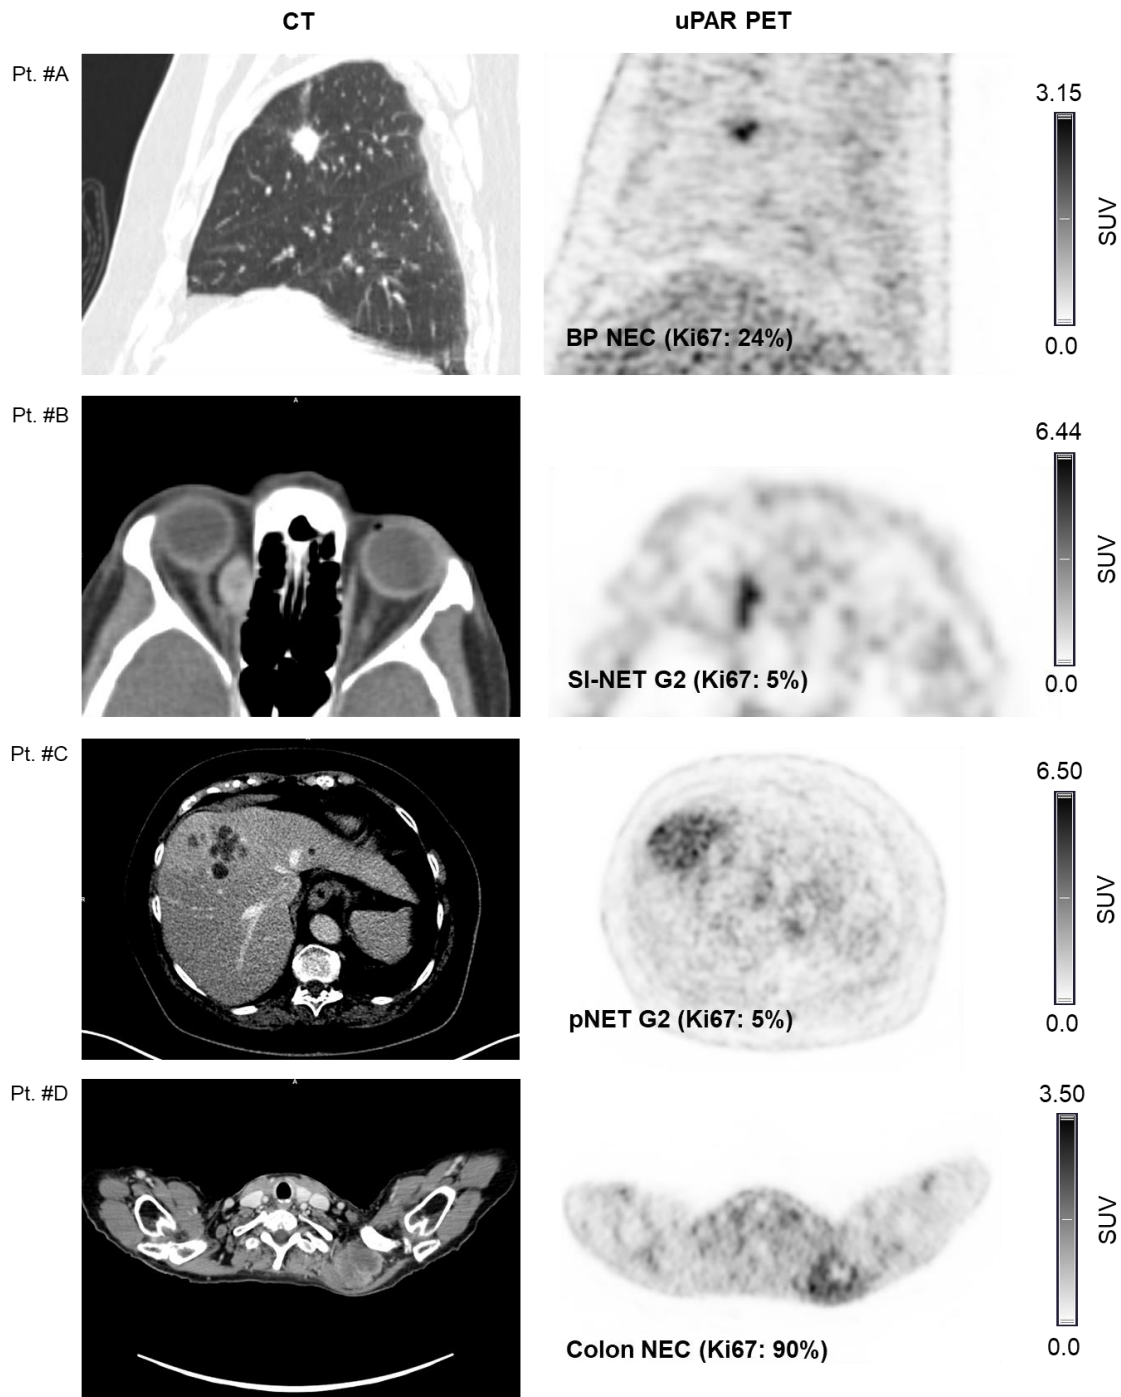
Representative examples of uPAR PET/CT imaging. CT (left column) and uPAR PET (right column) in 4 patients (#A-D) with high and low grade NEN. The top of the individual scale bar corresponds to the SUV_{max} value of the tumor. Pt. #A: Bronchopulmonary NEC (Ki67: 24%). Pt. #B: Orbital metastasis from small intestine NET G2 (Ki-67: 5%); Pt. #C: Large liver metastasis from
